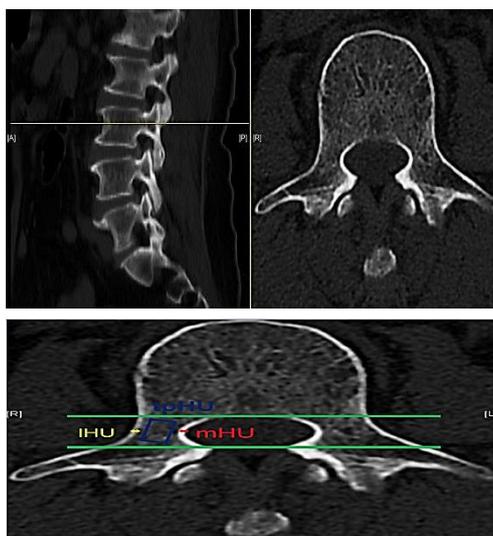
Example of CT HU value measurement in specific regions of lumbar pedical: The mean HU value of the trabecula bone area (tpHU), medial cortical bone area (mHU) and lateral cortical bone area (IHU) were measured on the mid-axial images of each vertebral pedical through PACS. The mid-axial images of the any given vertebral pedical from L1 to L4 were derived and followed by locating the sagittal images of the largest supra-inferior diameter.
